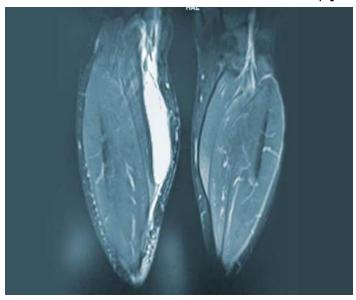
Tibiofibular MRI Confirming Morel-Lavallée Lesion with Ultrasound-Guided Aspiration of Serosanguineous Fluid Collection
